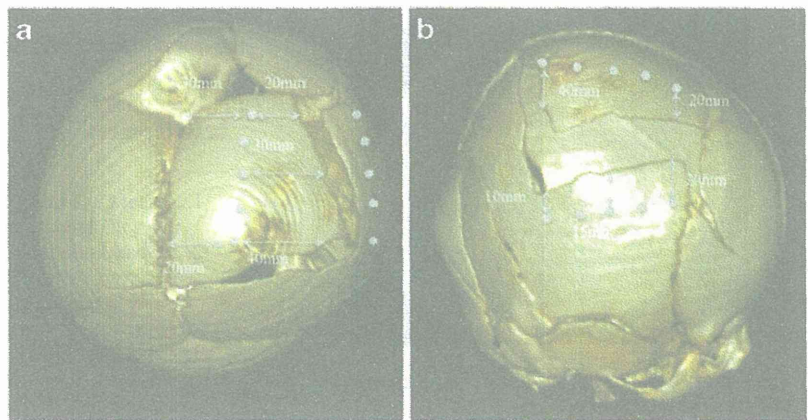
Three-dimensional computed tomography images (a, b) showing distance measurements to the dural defect at the end of the bone
